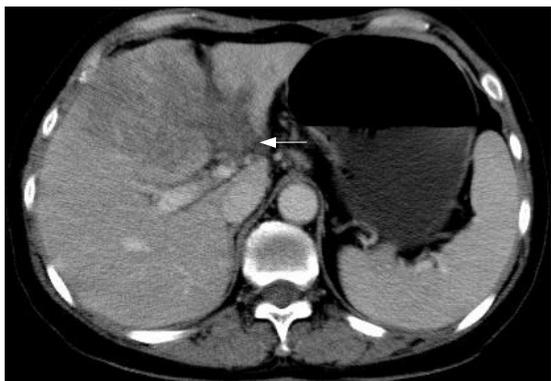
Portal phase of contrast-enhanced CT demonstrating the left portal vein tumor thrombus (white arrow).
